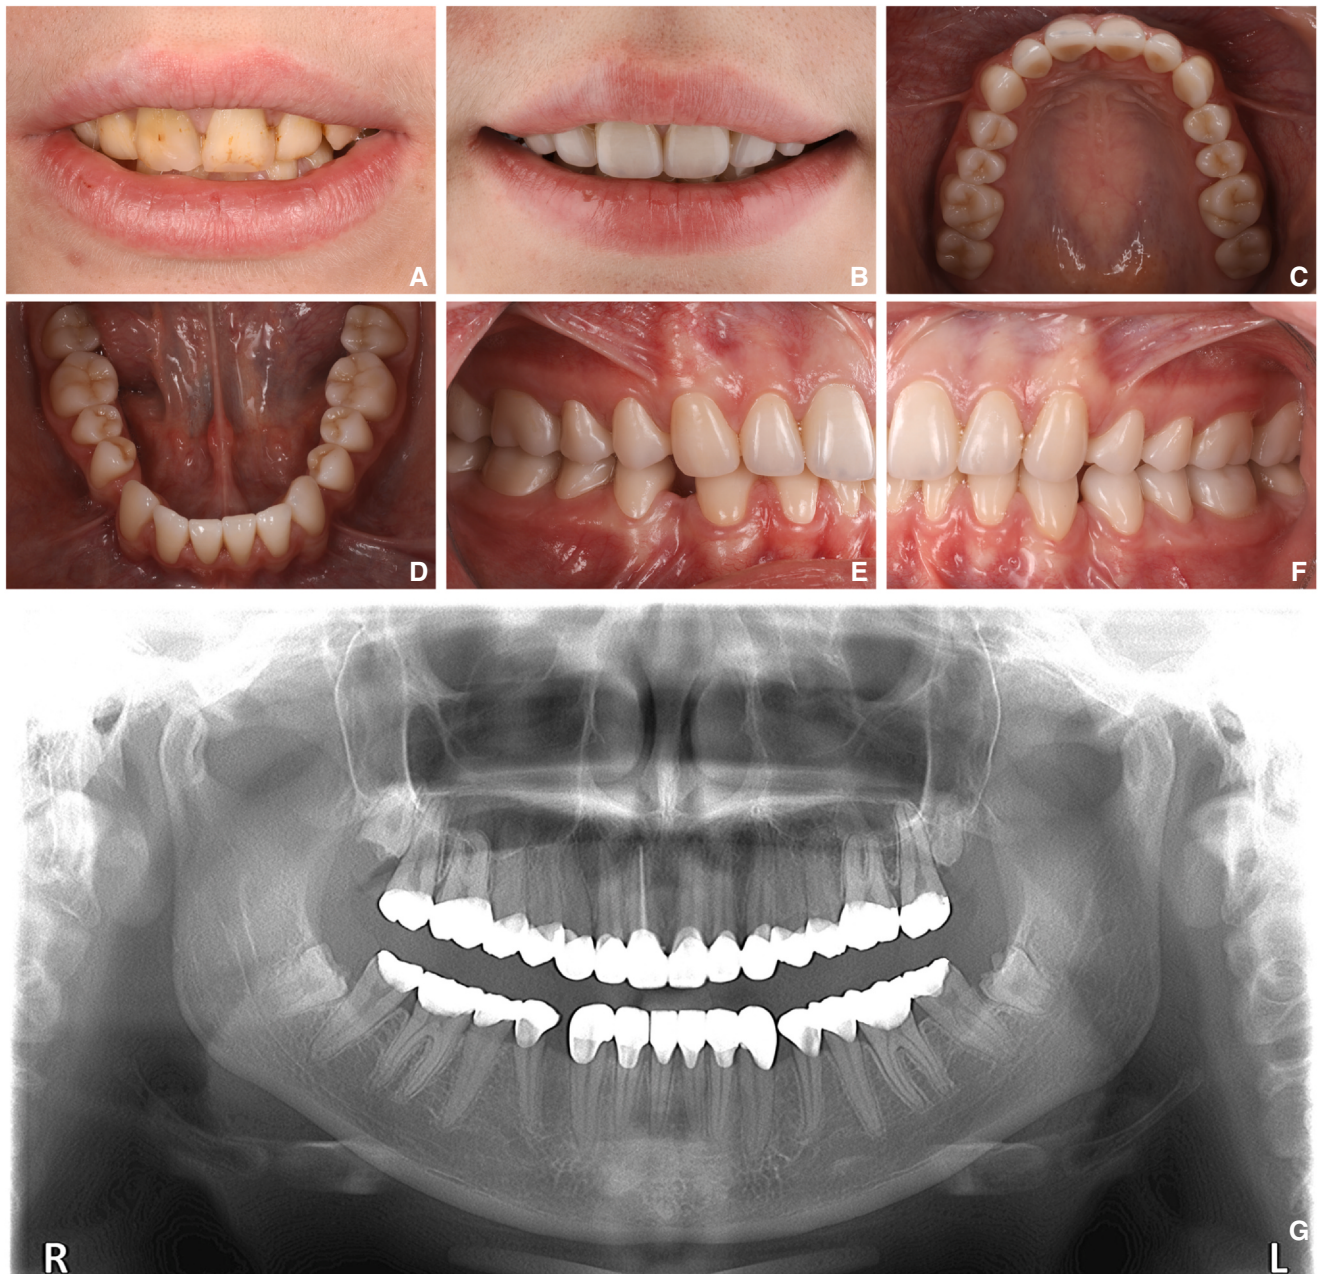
Clinical presentation. A, Initial extraoral view. B, Postoperative extraoral view. C, Postoperative maxillary occlusal view. D, Postoperative mandibular occlusal view. E, Postoperative lateral view F, Postoperative lateral view G, Postoperative panoramic radiograph.
